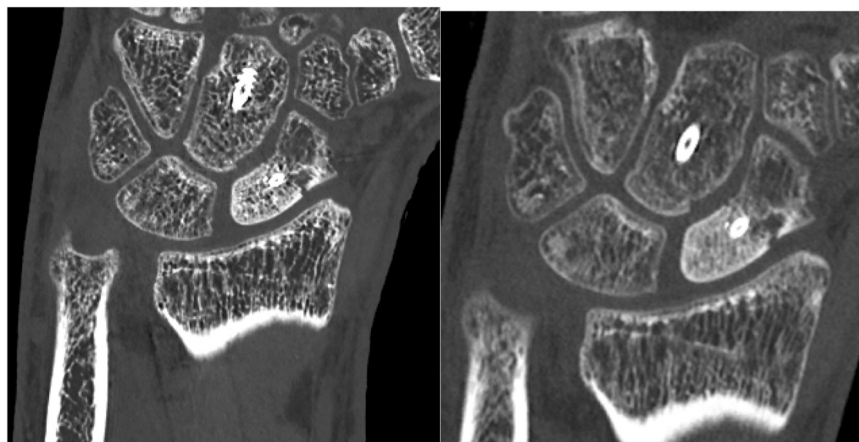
Twenty-three-year-old male with healing scaphoid fracture. PCD-CT (A) and energy-integrating detector (EID)-CT (B) of the right wrist both scanned on the same day. Cortical and trabecular features are more distinct on the PCD-CT image. PCD-CT, photon-counting detector-computerized tomography.
